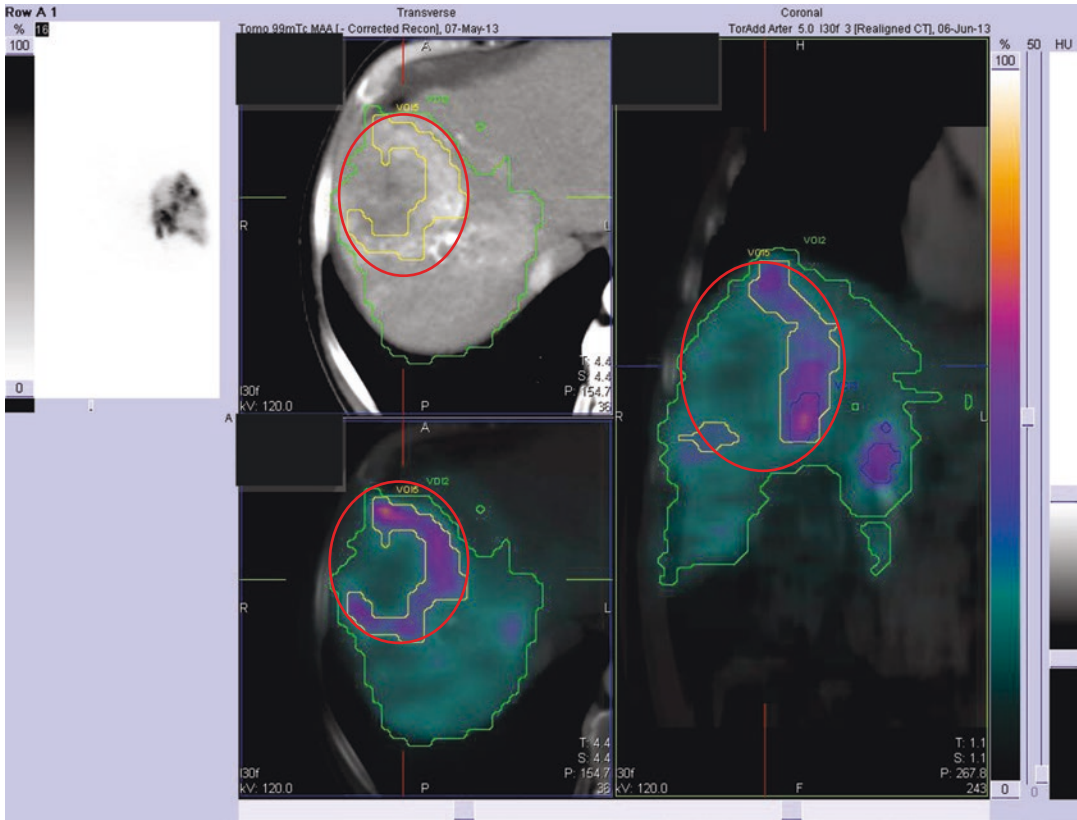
Two possible segmentation methods for an HCC lesion with a necrotic core. The yellow line shows the perfused region (SPECT with threshold). The red line shows the CT-based morphological volume
